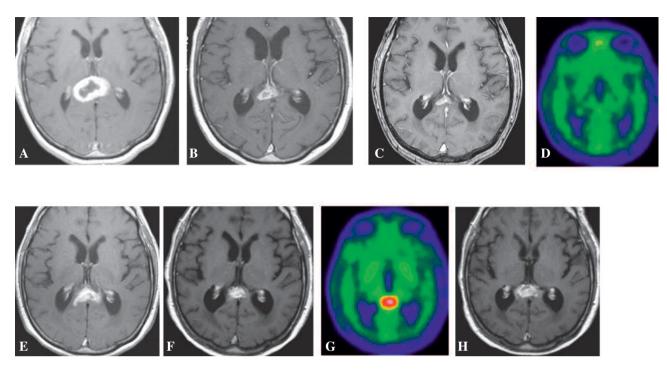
Following the occurrence of problems with her equilibrium and episodes of confusion, this 68 year old female patient was diagnosed in March 2007 with a gadolinium enhancing tumor located in the splenium corpus callosum (A). A stereotactic biopsy revealed glioblastoma without EGFR gene amplification. Treatment consisted of fractionated radiation therapy  $(30 \times 2 \text{ Gy})$  with concomitant daily temozolomide (75 mg/m²/day) followed by 6 adjuvant cycles of 5 out of 28 day temozolomide (administered at a daily dose of 200 mg/m²). Treatment was well tolerated and sequential MRI of the brain showed tumour regression. The residual gadolinium enhancing mass at the end of temozolomide therapy (B) continued to shrink during the following 5 months (C) and no uptake was revealed on PET imaging with an amino-acid tracer (fluorinated fenyl-methyl-alanine, FMP) (D). Nine months after the end of adjuvant temozolomide, progression of the glioblastoma was observed along with recurrent clinical symptoms (E). Temozolomide was reinitiated (5 out of 28 day regimen at) and resulted again in radiologic regression with symptomatic improvement (F). However, at the time of best radiological response, following 8 cycles of temozolomide, persistant uptake of FMP was still documented on PET (G). After 10 treatment cycles, progression was documented under temozolomide treatment.
